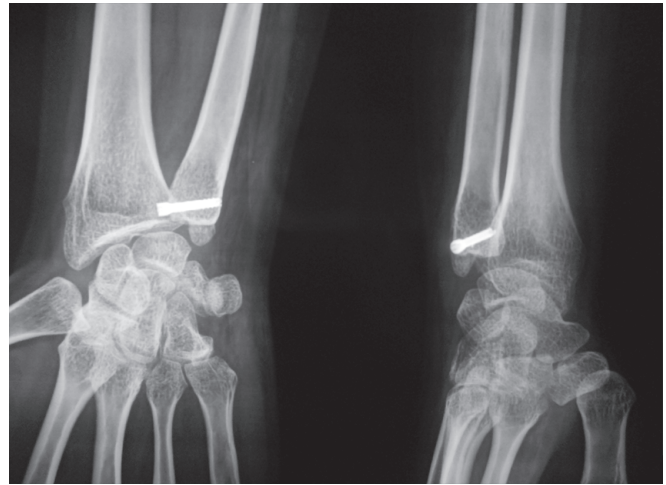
Ten weeks postoperative X-ray left wrist posteroanterior (in pronation) and lateral view showing fracture union
